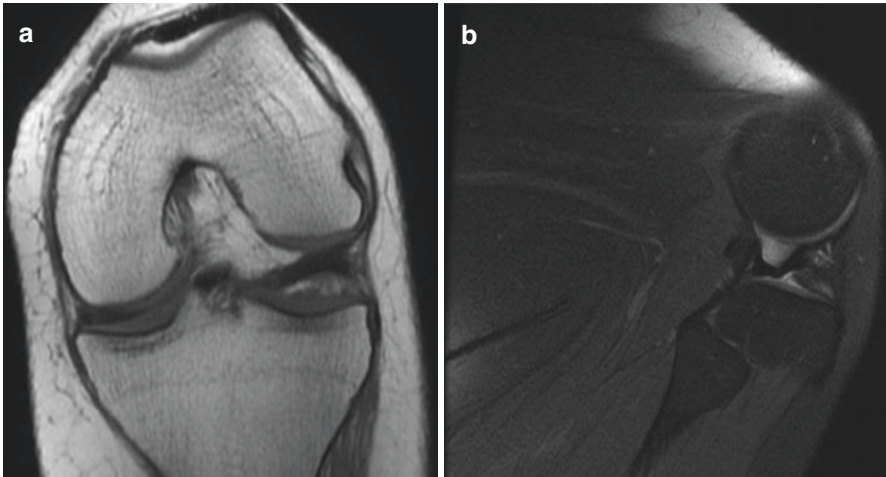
Coronal (a) and sagittal (b) MRI demonstrating a flipped lateral meniscus with the knee in a locked position
